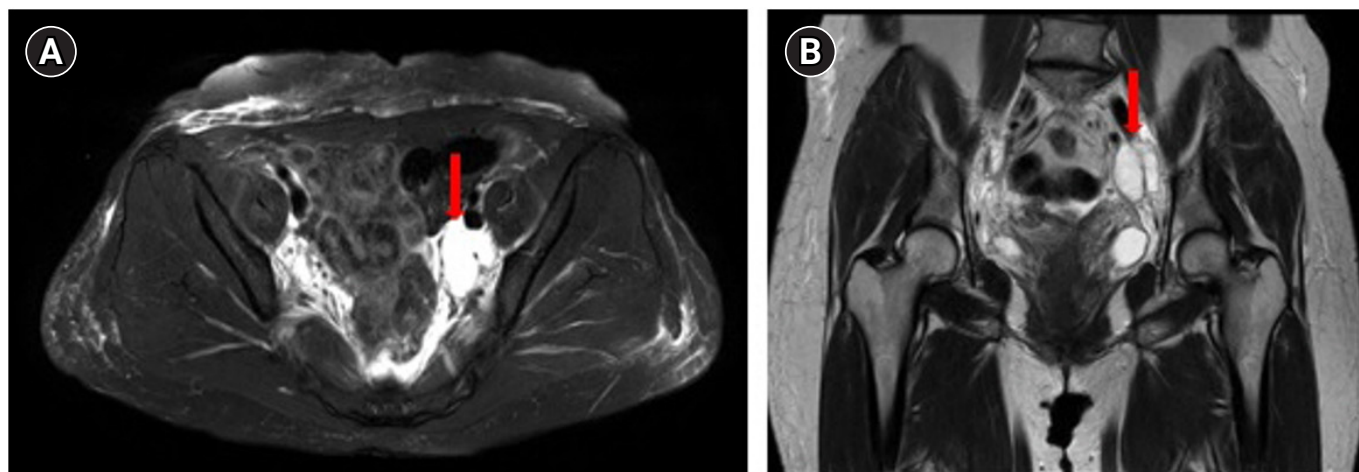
Axial and coronal views of pelvic magnetic resonance imaging show a 3.2 × 3.2 × 4.2 cm lobulated cystic lesion, suggestive of lymphocele (indicated by the arrows), at the left pelvic wall. (A) Suggestive lymphocele from axial view and (B) suggestive lymphocele from coronal view.
